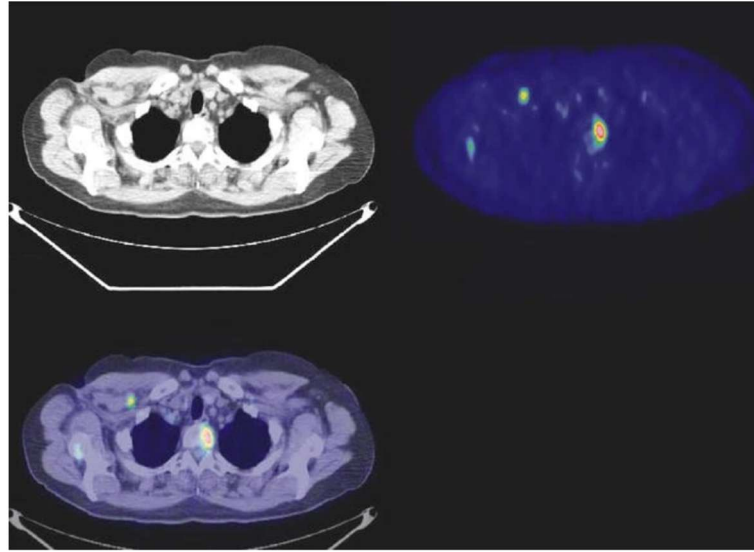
Patient treated for breast cancer. Bone and supraclavicular lymph node metastases were detected by PET/CT: CT (top left), PET (top right) and fused PET/CT (bottom left) [23]. (Reuse with permission)
